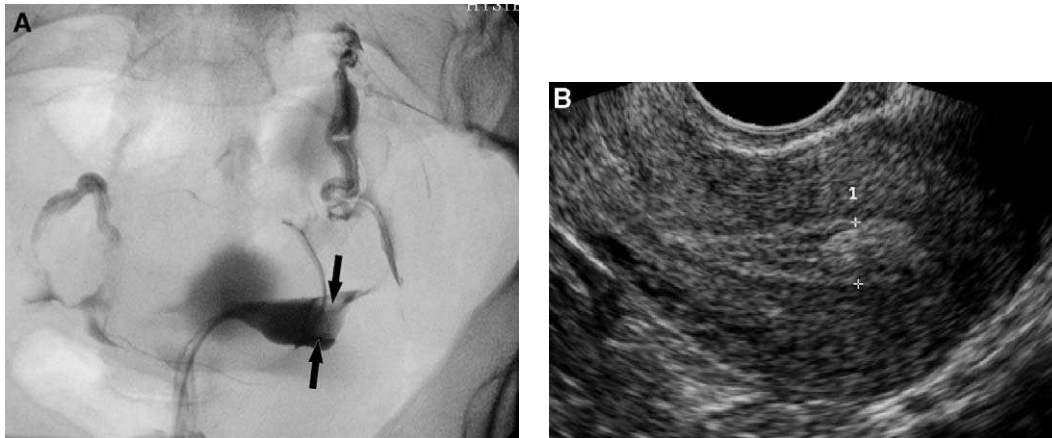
Endometrial polyp demonstrated by (A) hysterosalpingography (arrows) and (B) transvaginal sonography (cursors).
